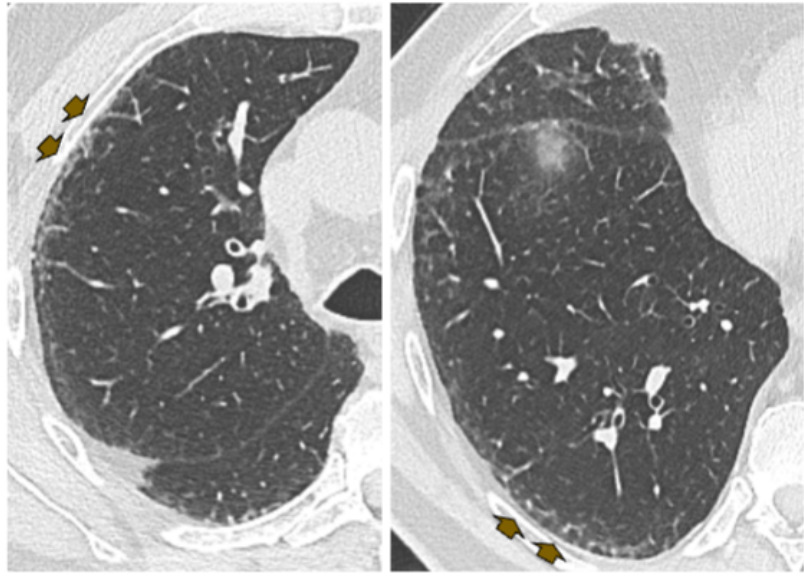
Axial CT images showing evidence of subpleural non fibrotic ILA: subpleural reticular opacities (arrows) with no overt signs of fibrosis/parenchymal distortion.
